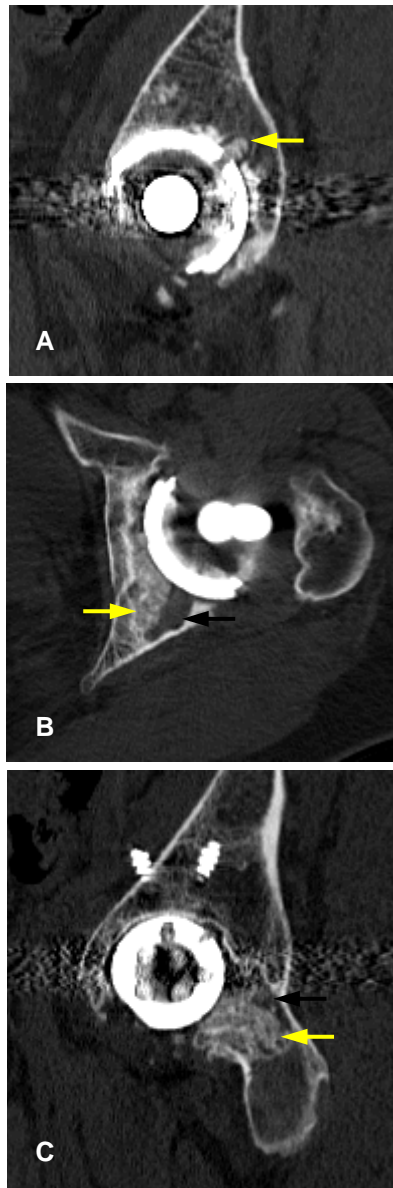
Axial and sagittal CT reconstruction images demonstrate osteolytic lesions partially filled with bone graft in: A, ilium, adjacent to an empty fixation screw-hole; B, medial and posterior walls of the acetabulum and C, in the ischium. Yellow arrows indicate bonegraft in place. Black arrows indicate non-grafted part of the osteolytic cavities.
